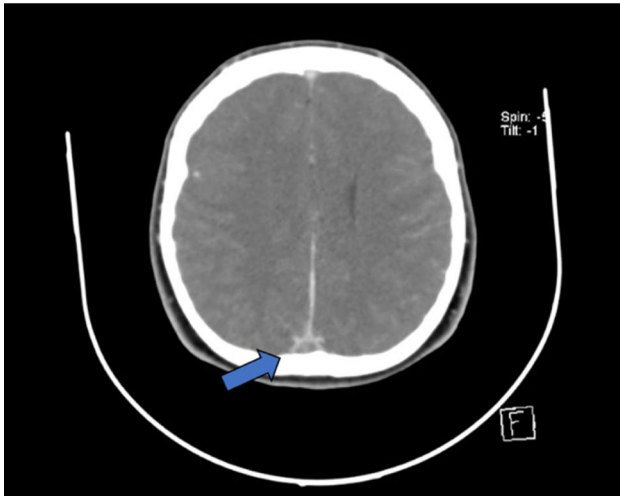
CT venography showing the empty delta sign (arrow)
